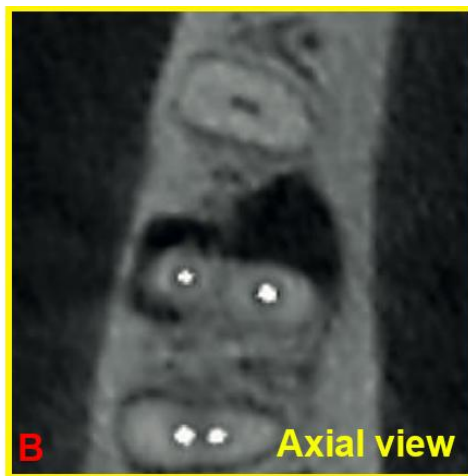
three-dimensional imaging of CBCT.
